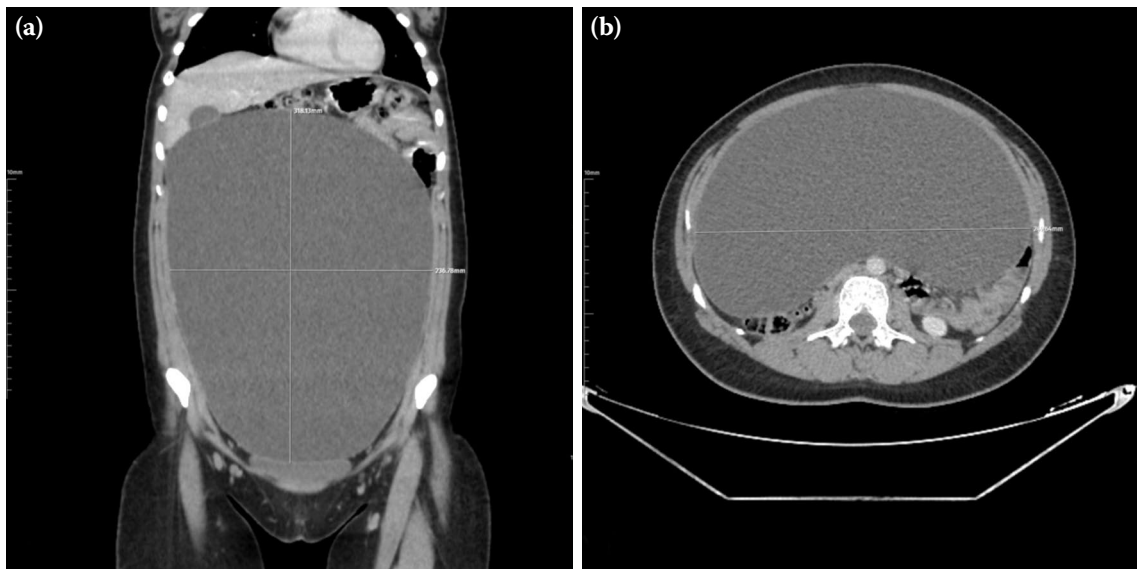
(a) Coronal and (b) axial computed tomography sections of a large unilocular cystic lesion originating from the right ovary.
